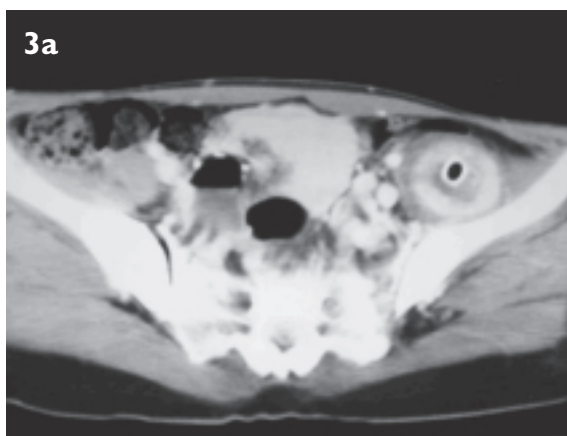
Follow-up CT scan performed 3 weeks later. (a) Enhanced axial CT scan taken at the level of the ilium, corresponding to Fig. 1d, shows an indwelling silastic tube and a much smaller iliopsoas abscess. (b) Enhanced axial CT scan taken at the level of the femoral lesser trochanters, corresponding to Fig. 1e, shows a small residual left iliopsoas abscess and a much smaller left gluteal abscess.
